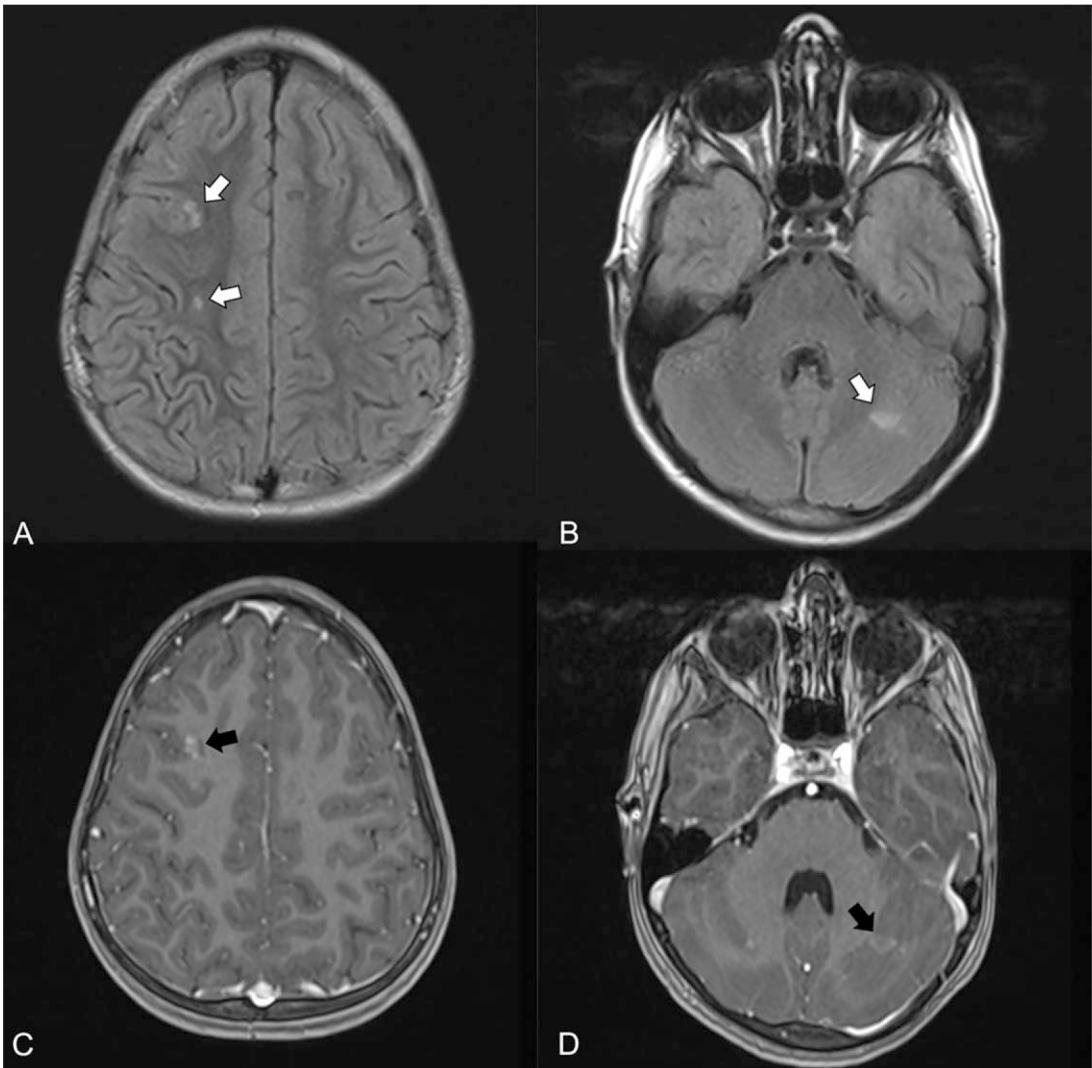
Brain MRI. Axial-plane Flair T2-weighted sequences reveal multiple cortico-subcortical lesions in the right frontal area (white arrow, A) and in the left cerebellar hemisphere (white arrow, B), with slight gadolinium enhancement of some lesions in T1-weighted sequences (black arrows, C and D).
